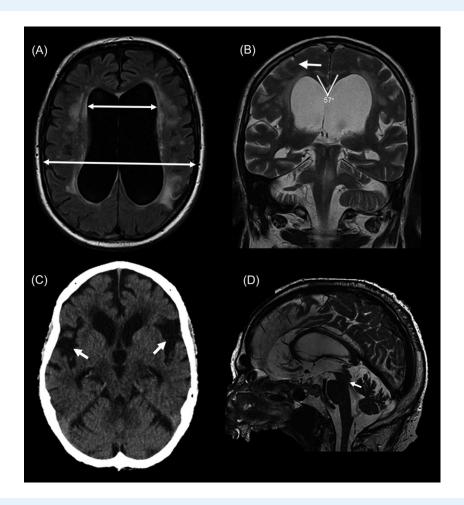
A series of magnetic resonance imaging (MRI) features are consistent with a diagnosis of idiopathic normal pressure hydrocephalus (INPH). (A) Disproportionate ventriculomegaly with an Evans ratio of 0.44 was measured by the ratio of the maximum frontal horn diameter to the maximal biparietal diameter (white arrows). (B) An acute callosal angle (labeled) and "tight" convexity with narrow cerebrospinal fluid spaces (white arrow) are shown. (C) Disproportionate enlargement of the Sylvian fissures (bilateral white arrows) is observed. (D) A T2-weighted MRI demonstrates an aqueductal flow void (white arrow).
